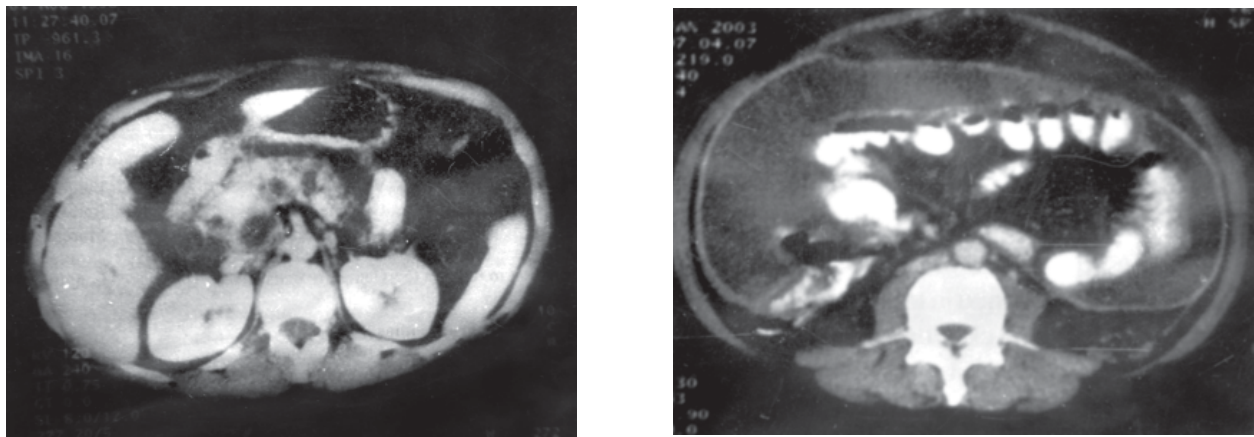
Abdominal CT scan showing caseous lymph nodes in tubercular lymphadenitis and tubercular peritonitis
